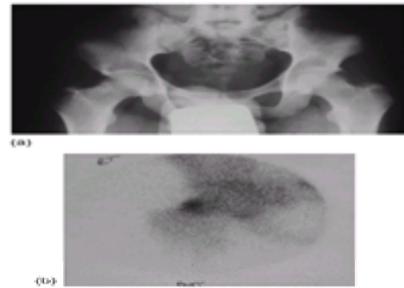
(a) Plain pelvic radiograph showing an osteoid osteoma of the femoral neck in an 18-year-old male who presented with a 3-month history of progressively worsening pain. (b) Radionuclide bone scan showing increased uptake of isotope by the lesion.
